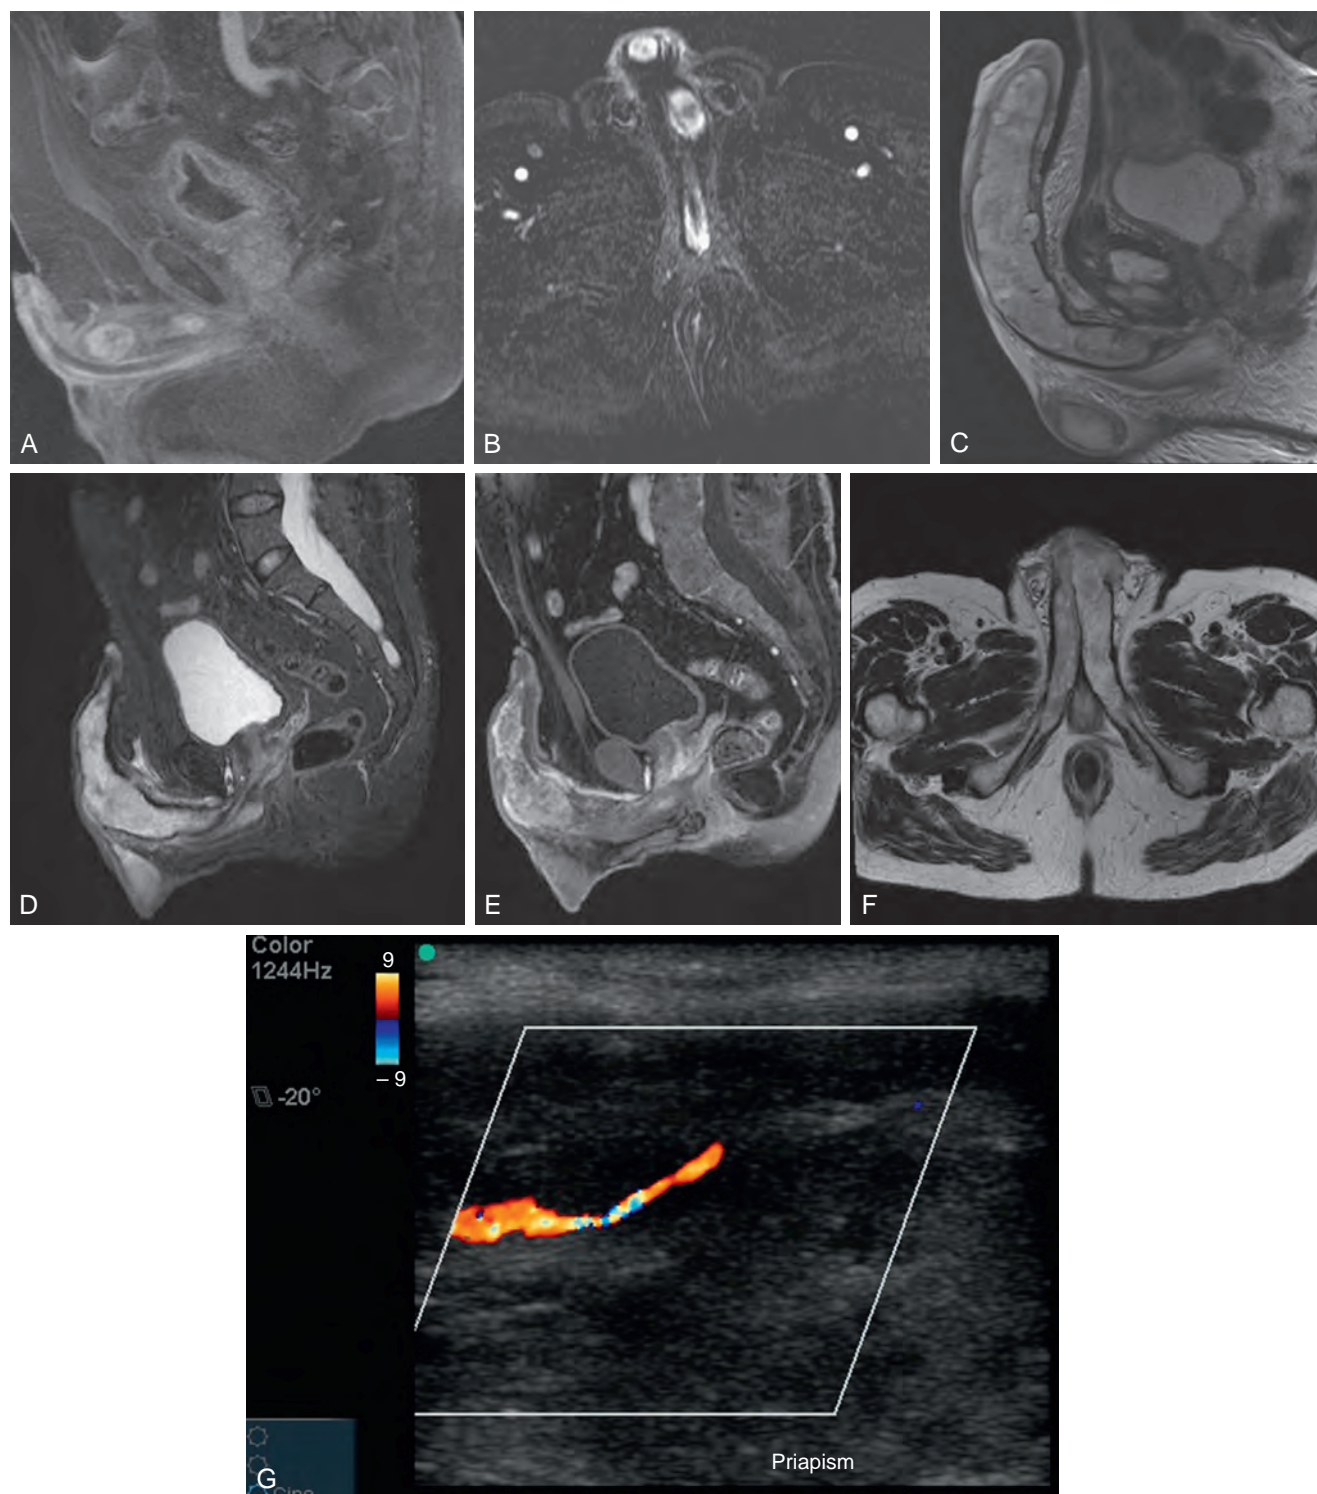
A, Sagittal magnetic resonance imaging (MRI) scan of the penis showing metastatic deposits of prostate cancer to the corpus cavernosum. B, Coronal MRI image from the same patient. Note the proximal and distal metastatic deposits of prostate cancer. C, T2-weighted MRI showing chondrosarcoma replacing corpus cavernosum. D to F, A 50-year-old white man with neurofibromatosis with a 6- to 12-month history of partial erection and progressive penile deformity. He was referred with a diagnosis of Peyronie disease. Penile biopsies showed malignant peripheral nerve sheath tumor or neurofibrosarcoma. T2- and T1-weighted MRI images show large irregular masses replacing corpora cavernosa. G, Color Doppler imaging shows irregular right cavernous artery with high flow. (C, Courtesy David Ralph.)
